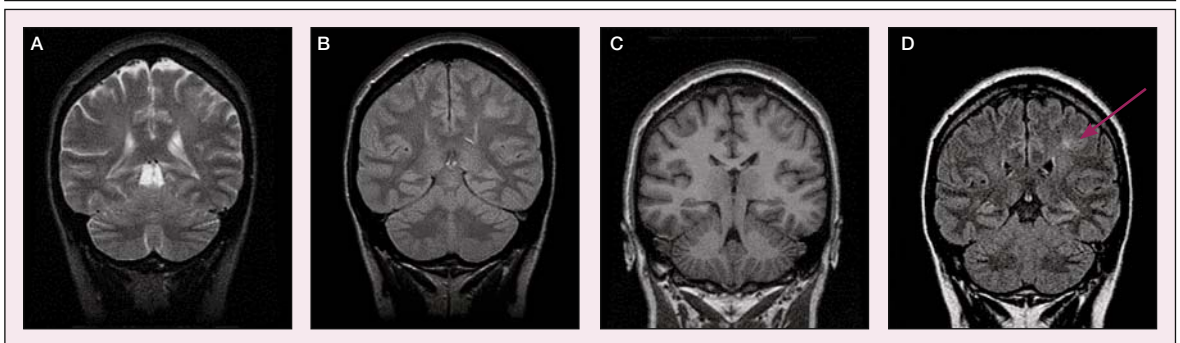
The patient's left is on the right of the images. The patient is a 50-year-old man with a 25-year history of focal motor seizures involving the right hand. The T1-weighted (C), T2-weighted (A) and proton-density (B) images were read as normal. On the FLAIR scan (D) it is evident that there is an area of increased signal in the brain parenchyma in the left primary sensorimotor cortex (arrow).
